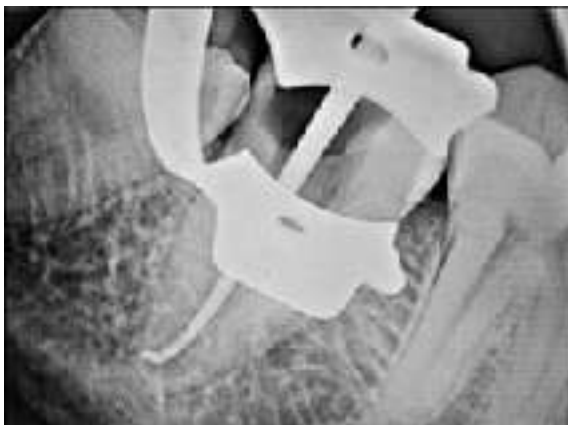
Radiograph of master cone #47.
